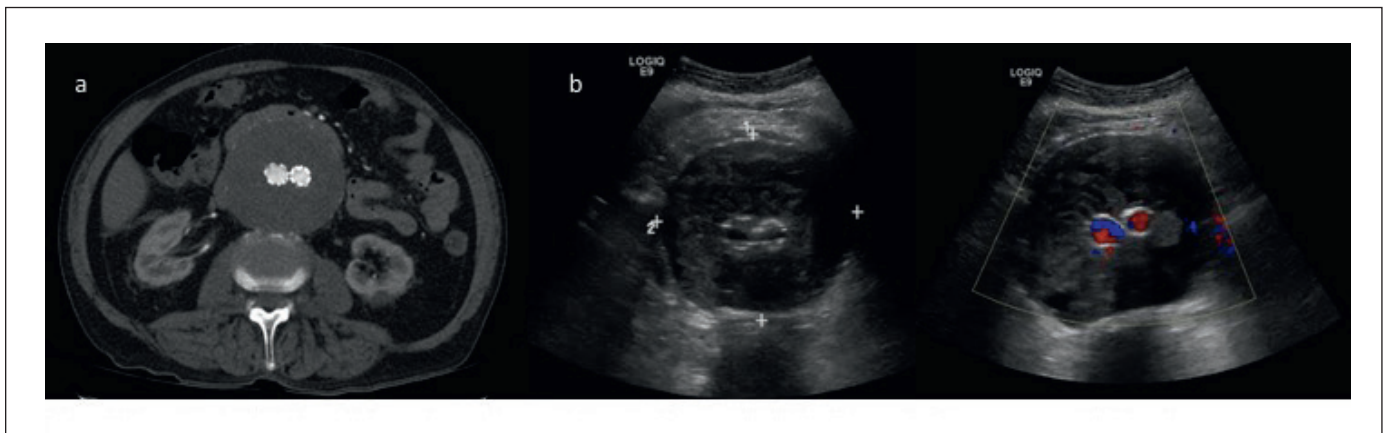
Type V Endoleak. (a) Axial CT image demonstrates endoleak repair with extension into the iliac vessels. The aneurysm sac is stable and measures up to 8.3 cm in maximal diameter with no evidence of endoleak. (b) One year follow-up ultrasound. Axial greyscale and Doppler sonograms demonstrate enlargement of aneurysm without evidence of endoleak. The aneurysm measures up to 9.1 cm which is increased from previous measurement of 8.3 cm on CT one year earlier. No source of bleeding was identified. This enlargement without evidence of overt source is in keeping with Type V classification.
